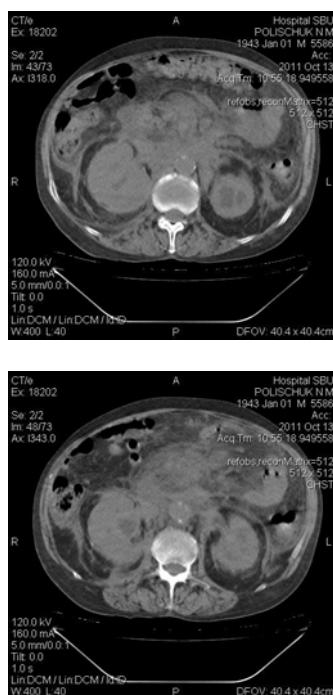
CT of the abdomen patient P. Infiltration of cellulose of front pararenal and perirenal spaces. "Turbid" mesentery. Ascites. Thickened Gerota's fascia
